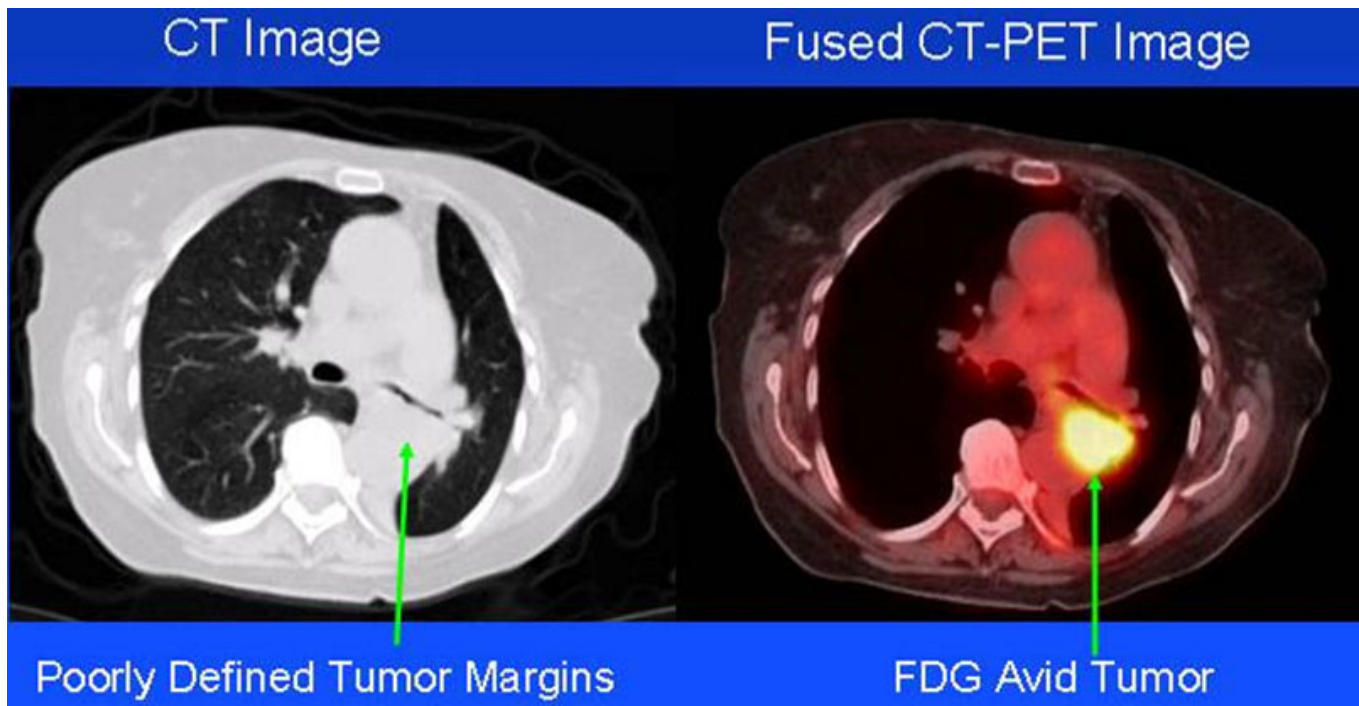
Fused CT-PET scans more clearly show tumors and are therefore often used to diagnose and monitor the growth of cancerous tumors.
